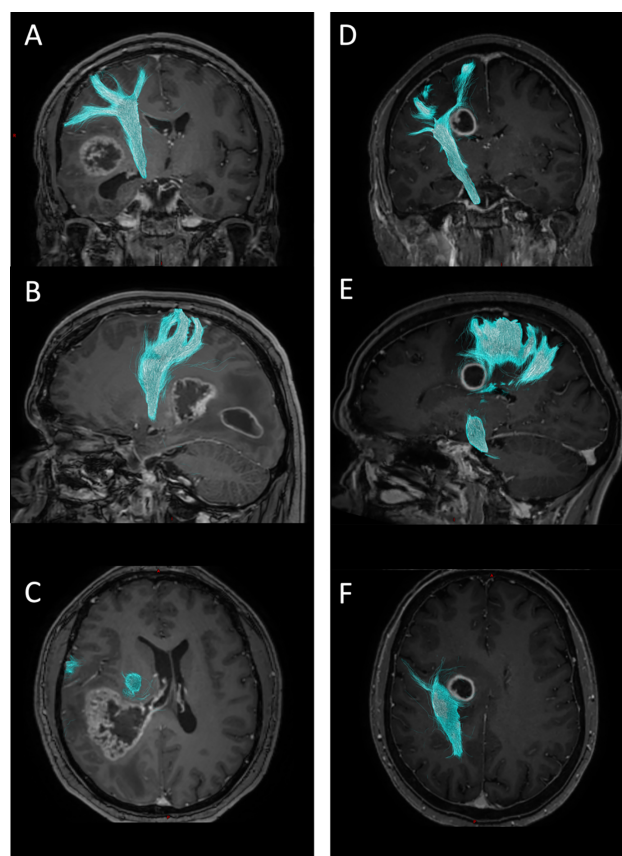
Example tractograms of the right CST (cyan). Preoperative contrast-enhanced T1-weighted MPRAGE sequence. (A–C) 34-year-old male patient with multifocal glioblastoma WHO grade 4 in the right hemisphere. NPS preoperative 2, postoperative 4. Preoperative median FA of the right CST 0.3972. (D–F) 62-year-old female patient with glioblastoma WHO grade 4 in the right hemisphere. NPS preoperative 2, postoperative 1. Preoperative median FA of the right CST 0.2706.
